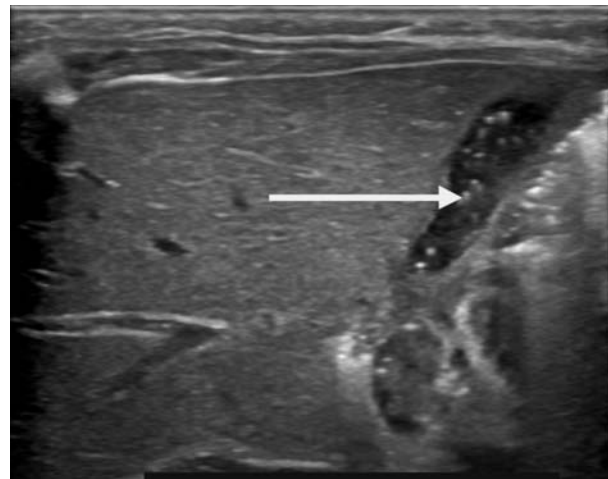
Ultrasonography of abdomen showing adenomyomatosis of gall bladder.
